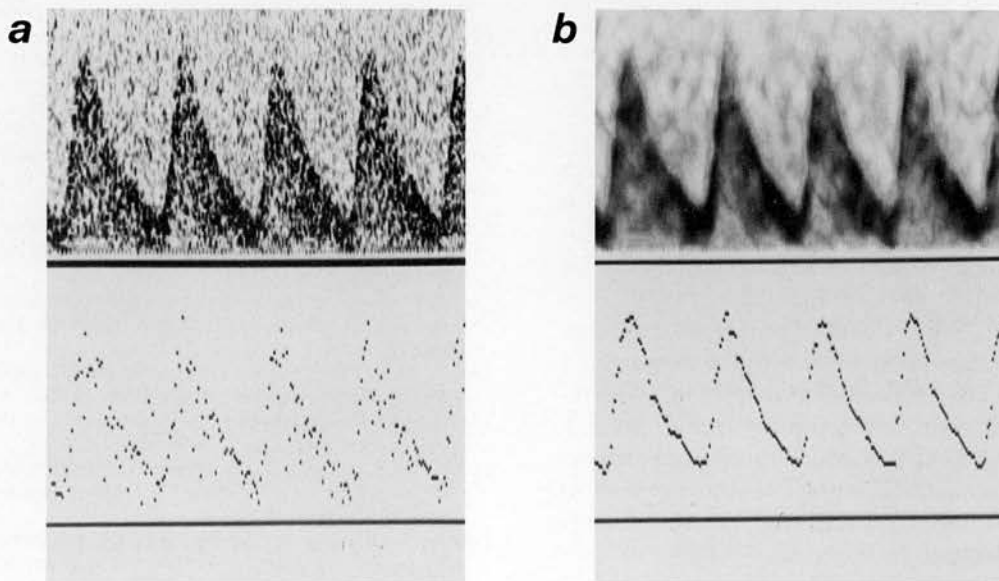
Doppler spectra of waveforms with a large amount of background noise, (a) before filtering and (b) after filtering with the optimal directional filter. The maximum frequency envelope is detected with fewer erroneous points when calculated from the filtered spectra of (b).
